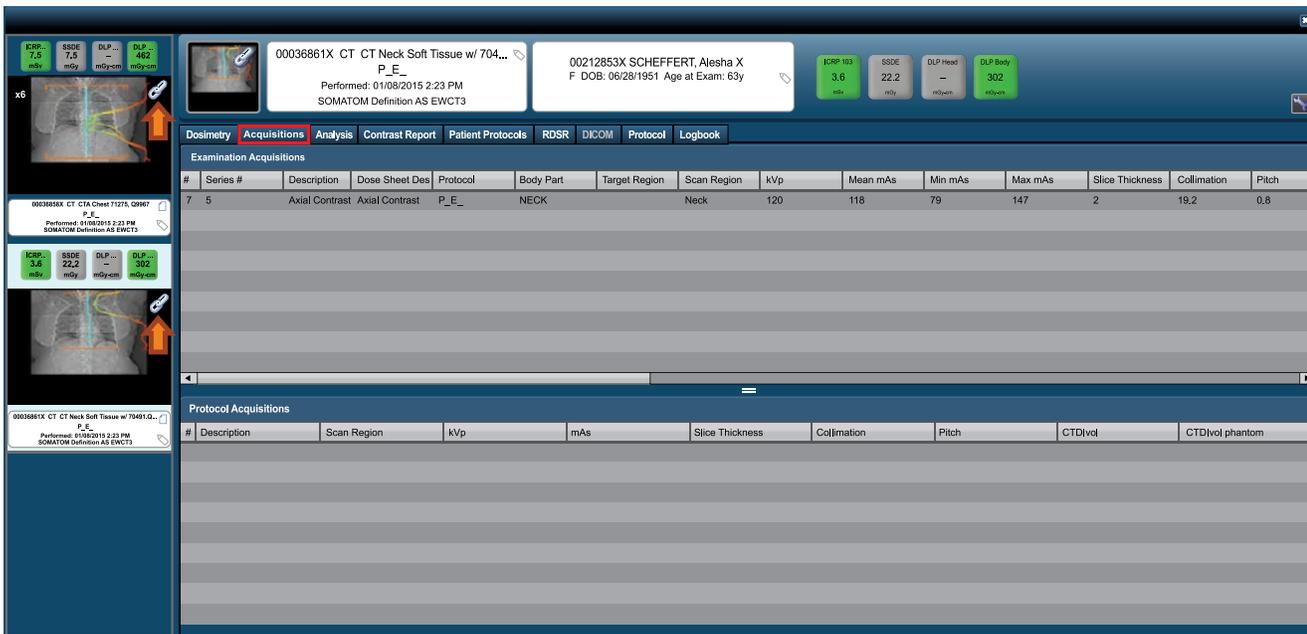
Scan Acquisition Tab CT Neck Study. We can quickly see these two studies are associated because they are linked as shown by the orange arrow located on radiographic image.
